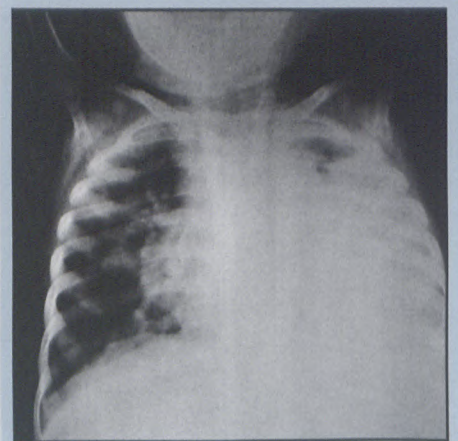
Admission chest radiograph demonstrating bilateral pulmonary consolidation more marked on the left, and mediastinal widening. No diaphragmatic calcification is seen.
